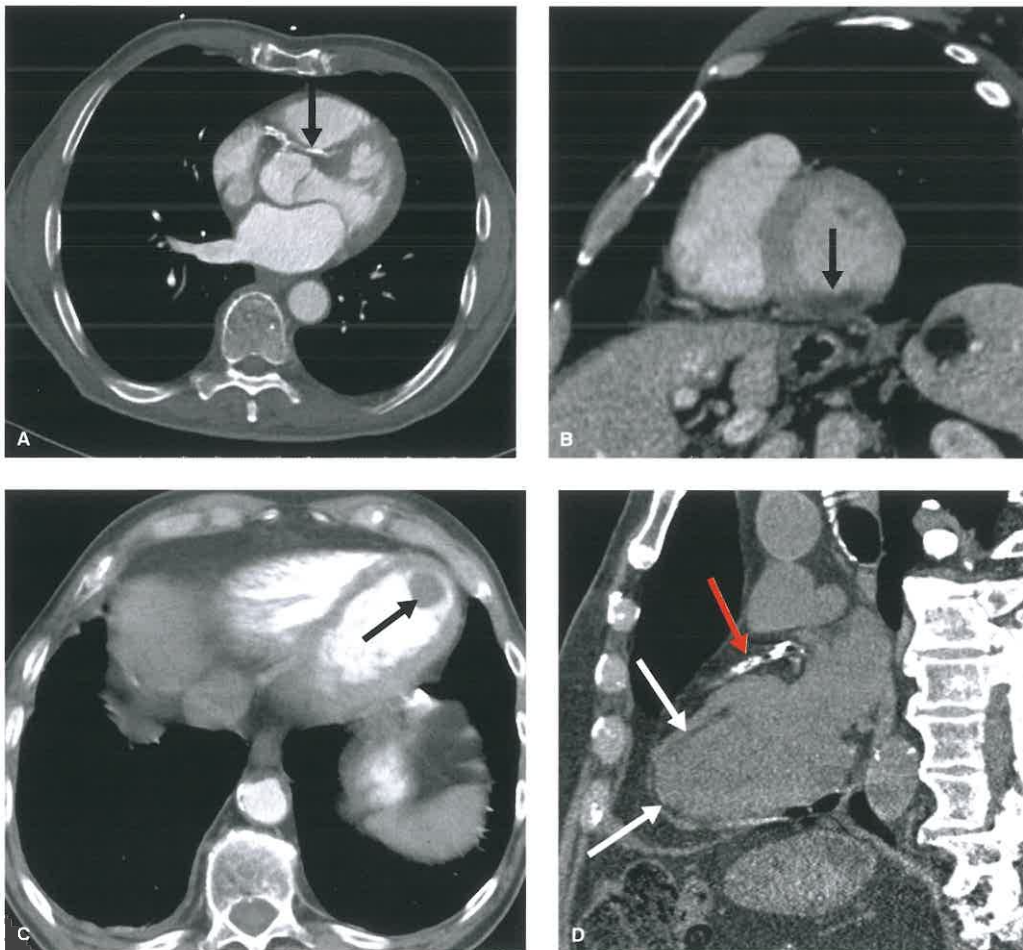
Cardiac Findings on Nongated CT Examinations. A: Axial image from a contrast-enhanced CT of the chest in a 71 year old shows an anomalous septal course of the left anterior descending coronary artery (*black arrow*). B: Short-axis reconstruction from a routine chest CT in a 59-year-old man shows subendocardial hypoperfusion in the inferior wall (*black arrow*). The patient had an acute MI 2 days prior. C: Axial image from an abdominal CT in a 63-year-old woman shows a left ventricular apical aneurysm with a 2-cm thrombus (*black arrow*). The finding was unknown to the primary team. D: Sagittal oblique MPR in an 85-year-old woman shows extensive calcification in the LAD territory (*red arrow*) with subendocardial fatty metaplasia of the associated myocardium due to old infarct (*white arrows*). Fatty metaplasia is a common finding and can be visualized with or without contrast.
